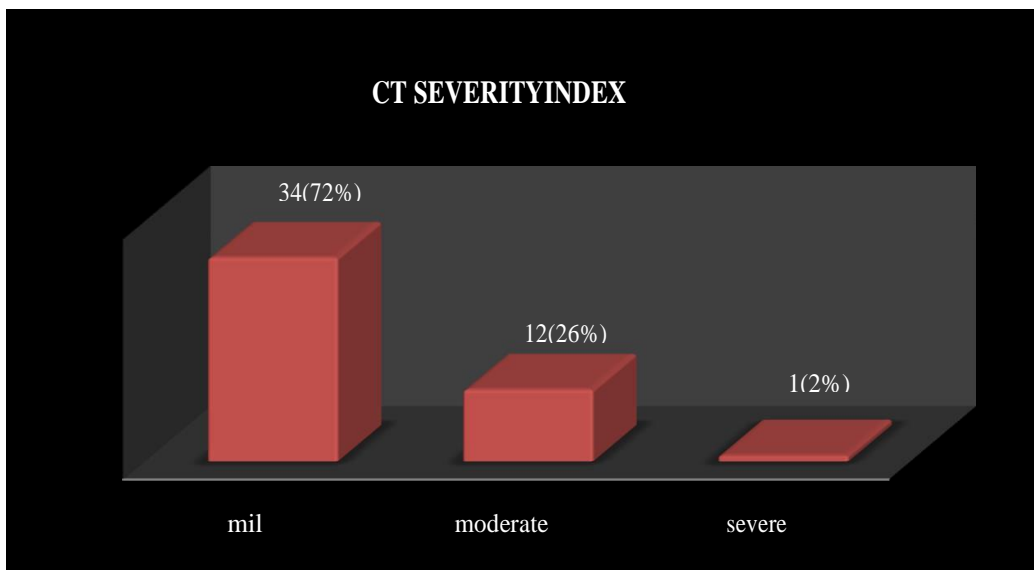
MODIFIED CT SEVERITY INDEX.
